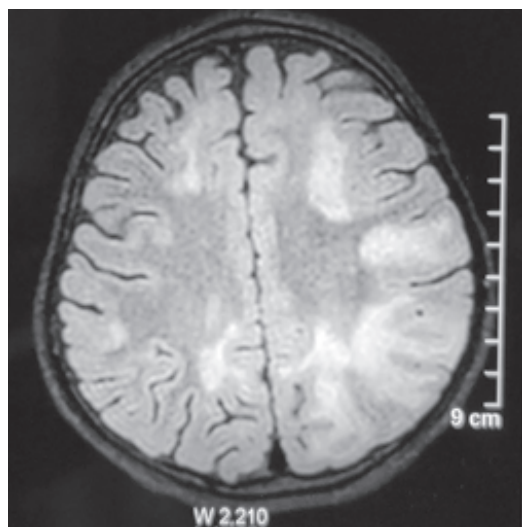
ADEM - MRI brain axial FLAIR image – Well / ill-defined multifocal white matter hyperintensities
